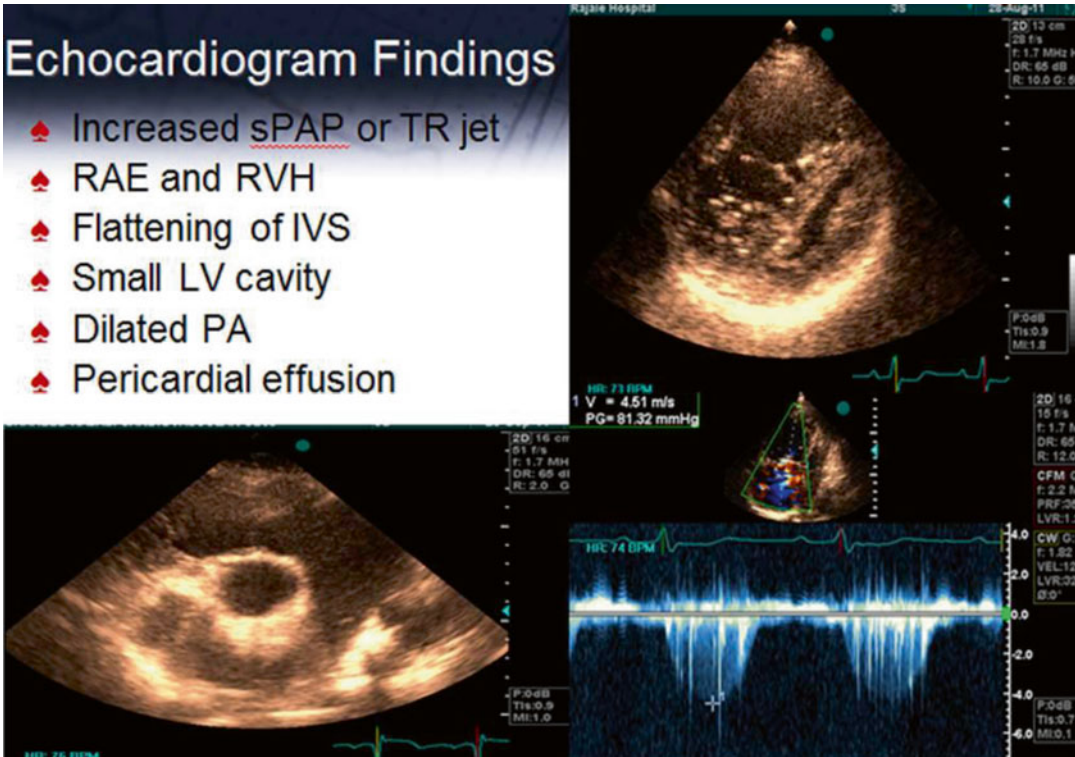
Showing additional echocardiographic variables suggestive of PH
